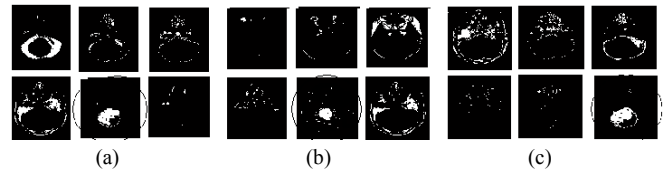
Tumor segmentation using EM for patient #8 in (a) T1 image using mBm, (b) T2 image using intensity, (c) FLAIR image using mBm, respectively. Tumor segments are circled.
